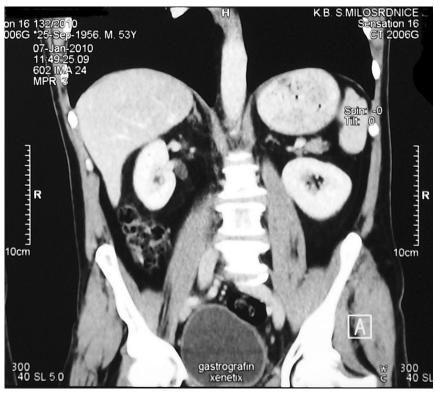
Post-treatment CT scans performed in intervals of 4-6 months show post-irradiation thickening of bladder wall with no signs of relapse.
